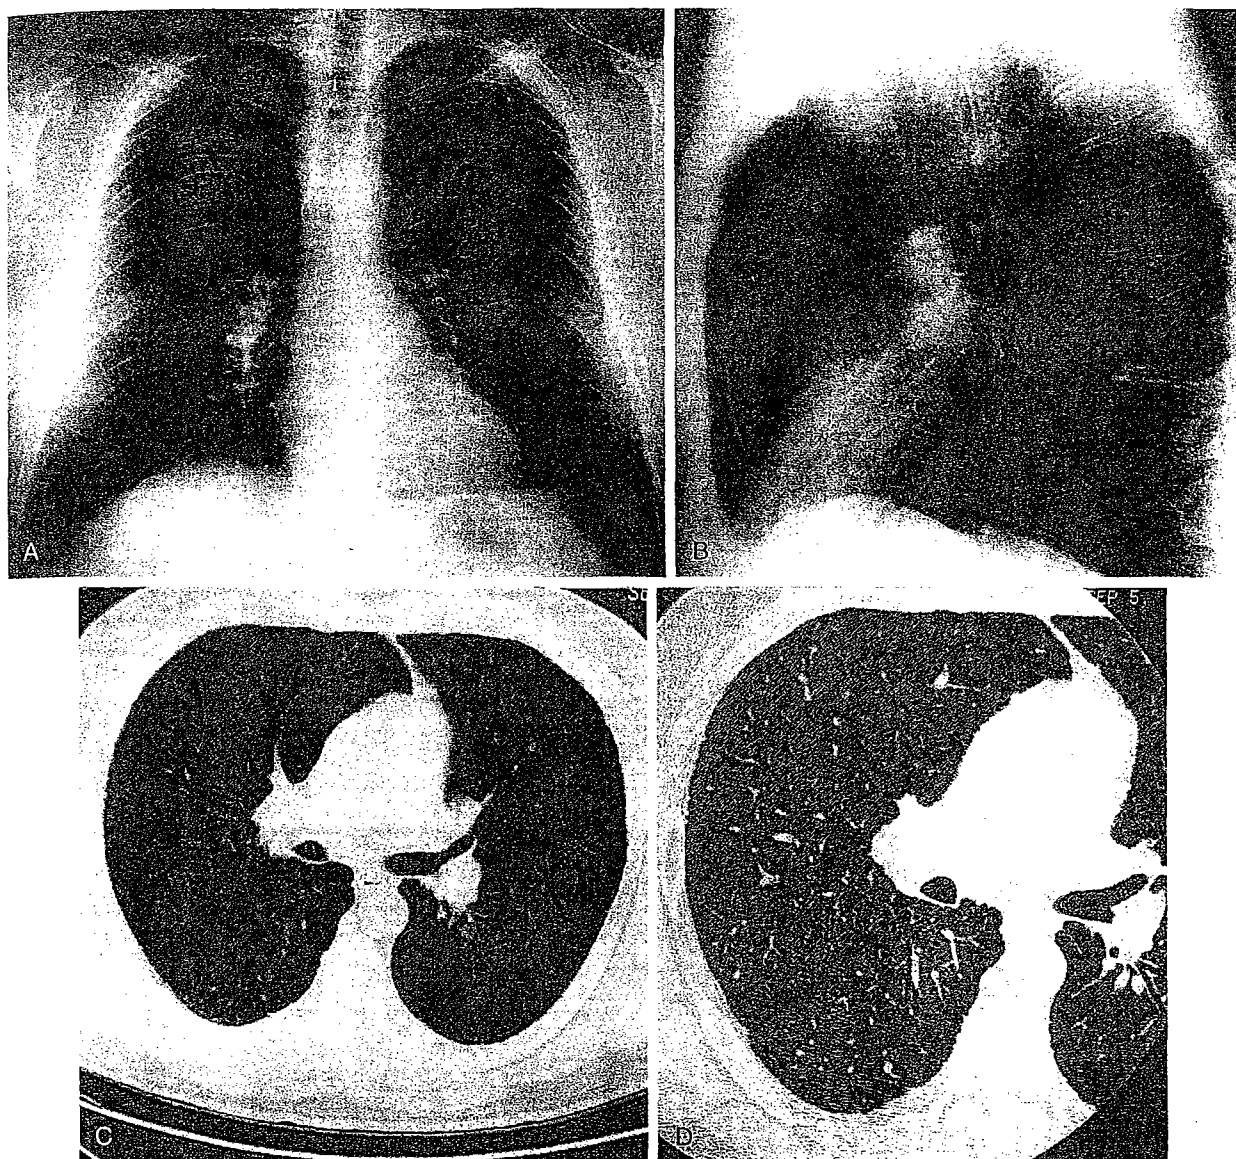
Berylliosis: Radiographic and CT Findings. Posteroanterior (A) and lateral (B) chest radiographs in a 46-year-old male ceramic plant worker show bilateral hilar adenopathy and fine nodules. The profuse fine nodules are confirmed on conventional CT (C) and HRCT (D) images. They are more evident on the 10-mm conventional CT image because more of them are contained within the imaging volume. The HRCT image, however, better demonstrates the tendency of the nodules to cluster along the visceral pleura, a distribution similar to that seen in patients with sarcoidosis. (Courtesy of Dr. David Lynch, University of Colorado Health Sciences Center, Denver, CO.)
